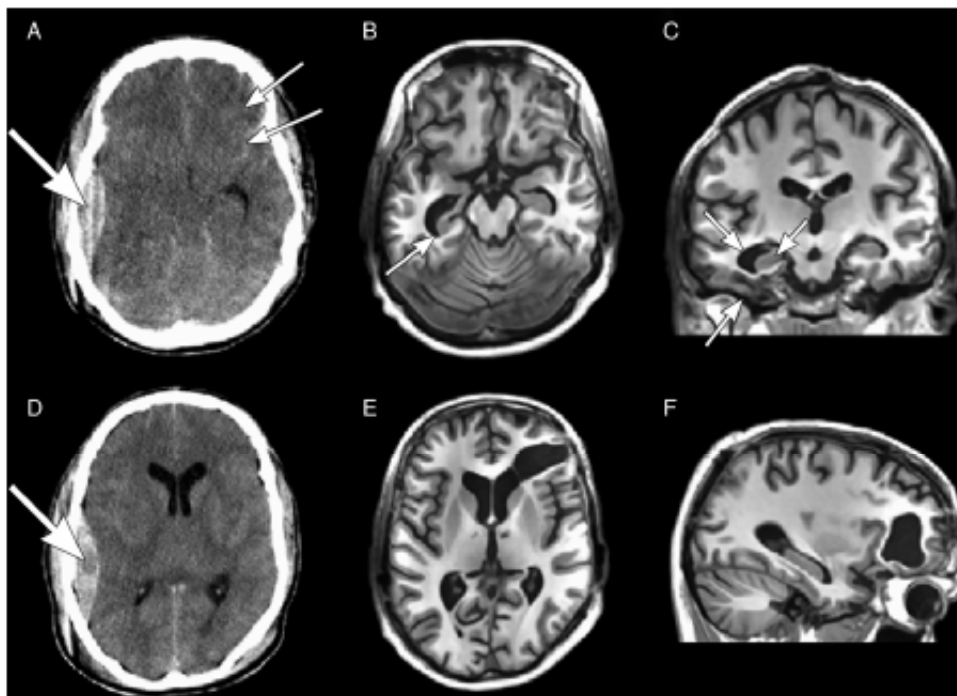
(A), (D) Day of injury axial CT scan showing an epidural hematoma (left arrow); (B), (E) follow-up MRI (20 months post-injury) at approximately the same level as the earlier CT, demonstrating significant structural and atrophic changes from the brain injury; (C) MRI coronal view depicting hippocampal atrophy and temporal horn dilation; (F) MRI sagittal view depicting a large cystic lesion in the frontal lobe and associated atrophic changes.
